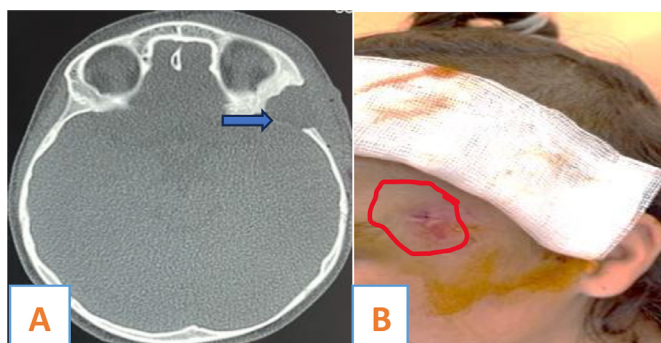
Postoperative CT scan bone window axial, resection of the intradiploic dermoid cyst (blue arrow) (A). The fistula skin scar (B) (red round).
